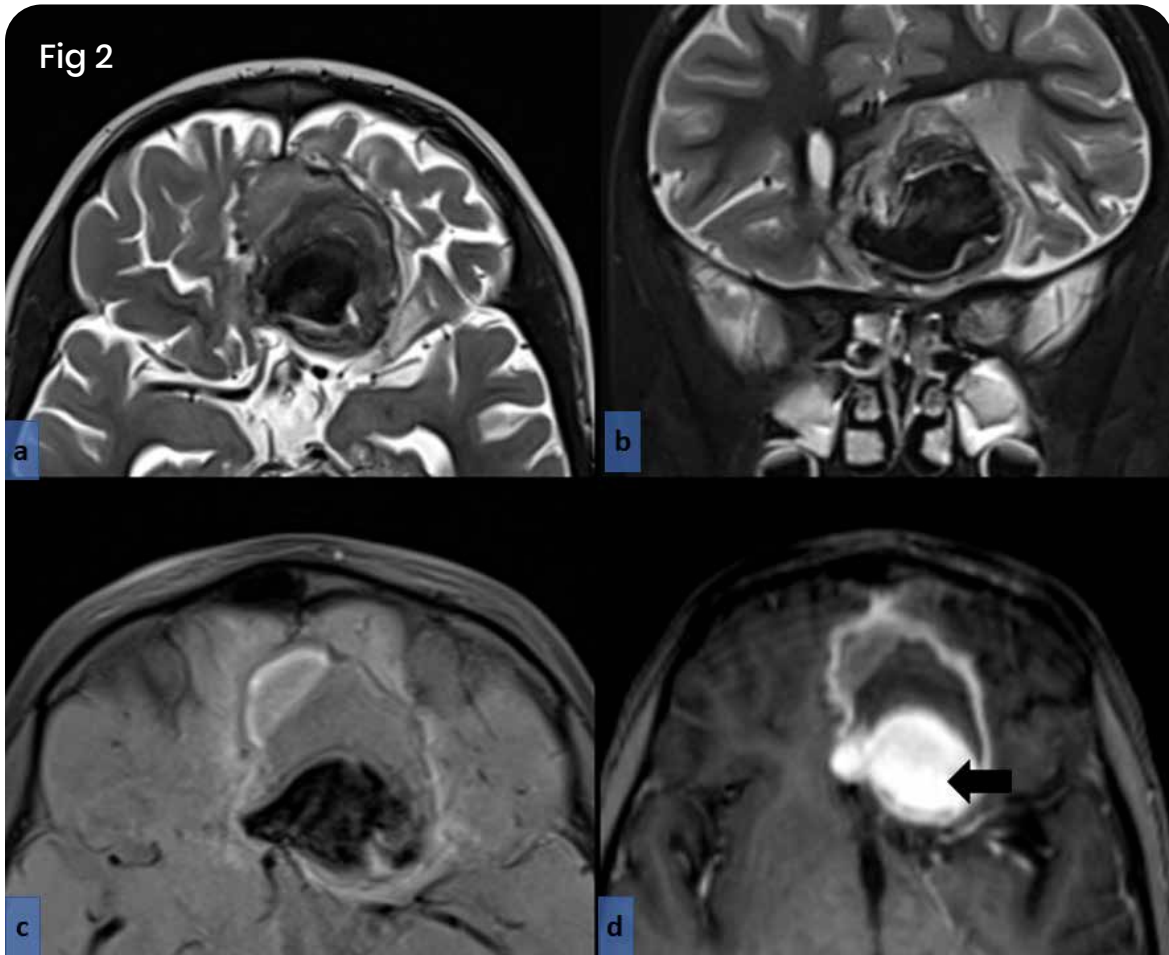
3 month follow up MRI after antifungal therapy showed interval response in size of cerebral component of infection with interval increase in T2 “flow void”. Note the intense enhancement of the intra-abscess aneurysm (arrow)
